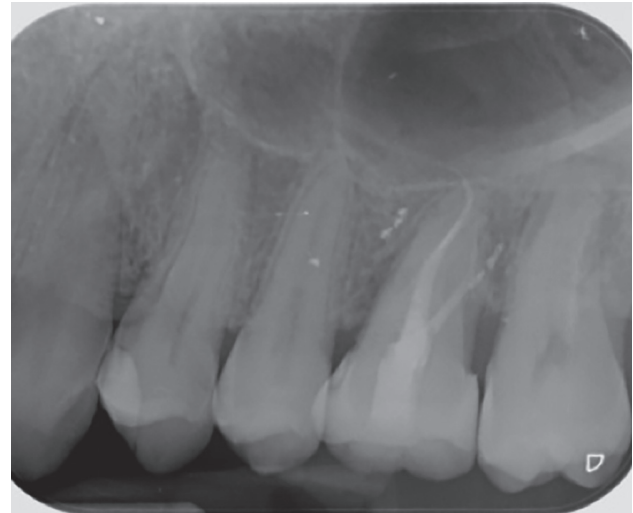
Periapical radiograph after 5 months of the autotransplant.
